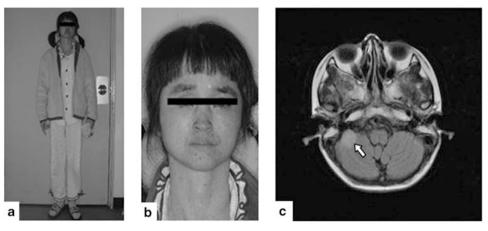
(a) Note the short stature. (b) Progeroid facies, multiple facial pigmented nevi, microcephaly, and mild micrognathism. (c) Magnetic resonance image (MRI) of the patient's cerebellum showing a 2 cm right cerebellar mass (white arrow).
